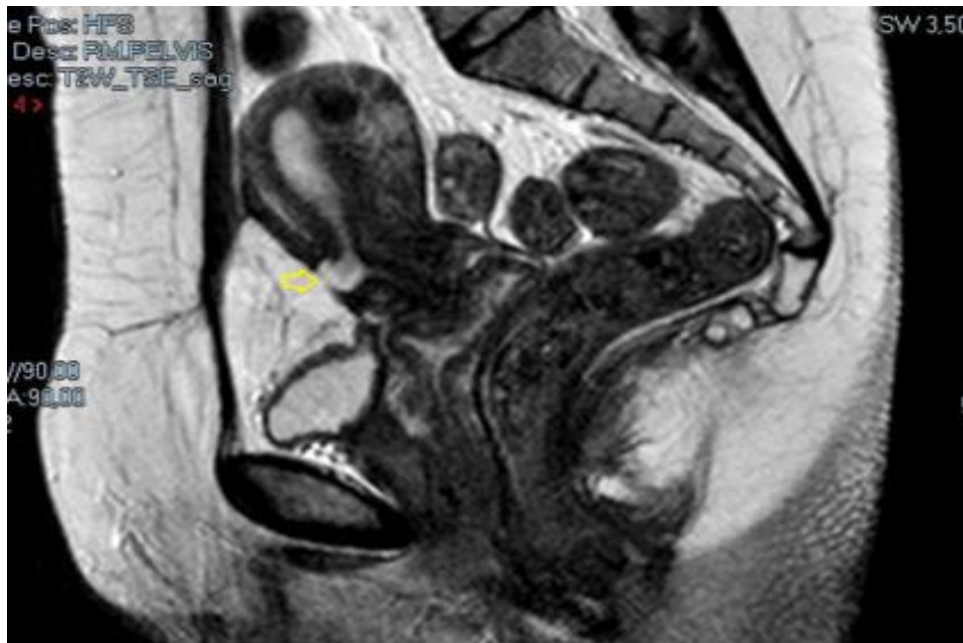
Isthmocele (arrow) as depicted by magnetic resonance imaging [44]
